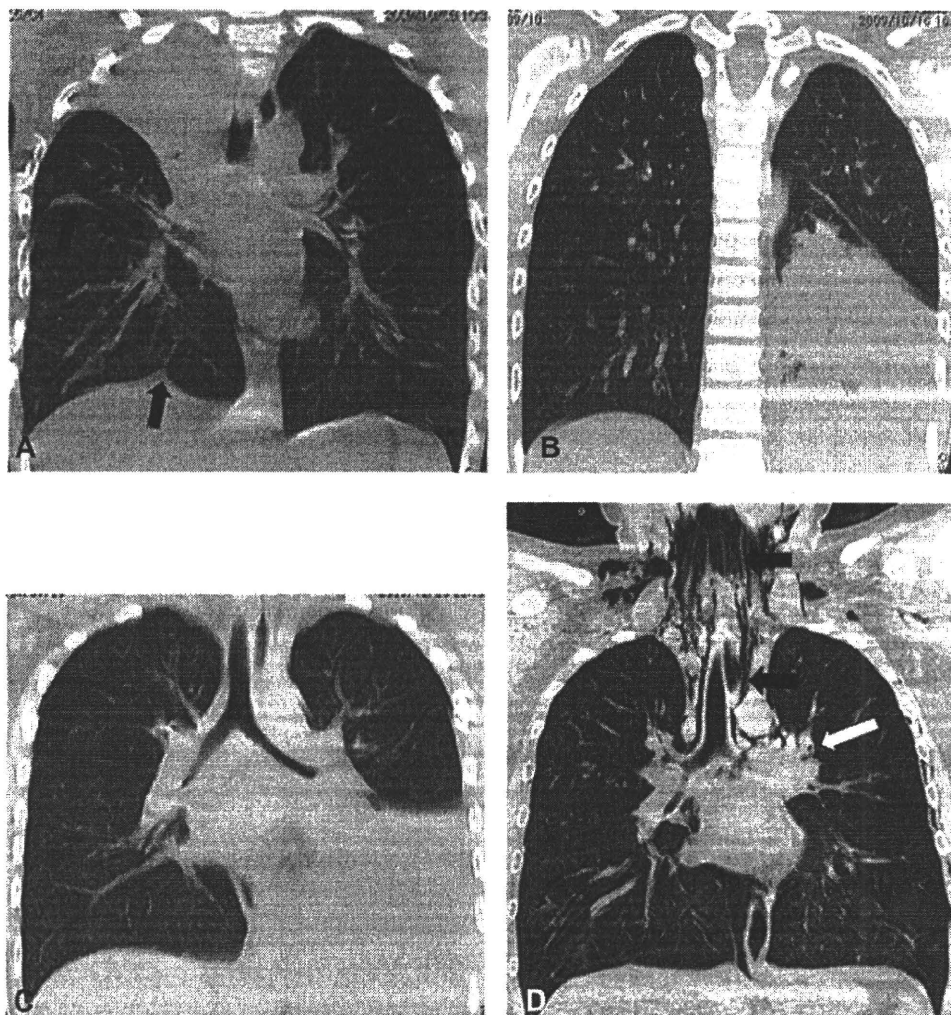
Representative coronal reformatted chest CT findings in subjects with 2009 pandemic H1N1 influenza viral pneumonia. (A) 8-y-old boy with pandemic H1N1 influenza admitted to the ICU because of respiratory distress, showing bilateral diffuse ground-glass opacity, atelectasis in right upper lobe and pleural effusion (arrows) in the right lung. (B) 7-y-old boy admitted with a 1-day history of fever, cough and dyspnoea, requiring oxygen administration, showing atelectasis of the left lower lobe. (C) 5-y-old boy admitted with a 1-day history of fever, cough and dyspnoea, showing atelectasis of left lower lobe and pleural effusion in the left lung. (D) 9-y-old boy admitted with a 1-day history of fever and dyspnoea, showing mediastinal and subcutaneous emphysema (arrows) and unilateral multifocal consolidation (open arrow) in left lower lobe.
